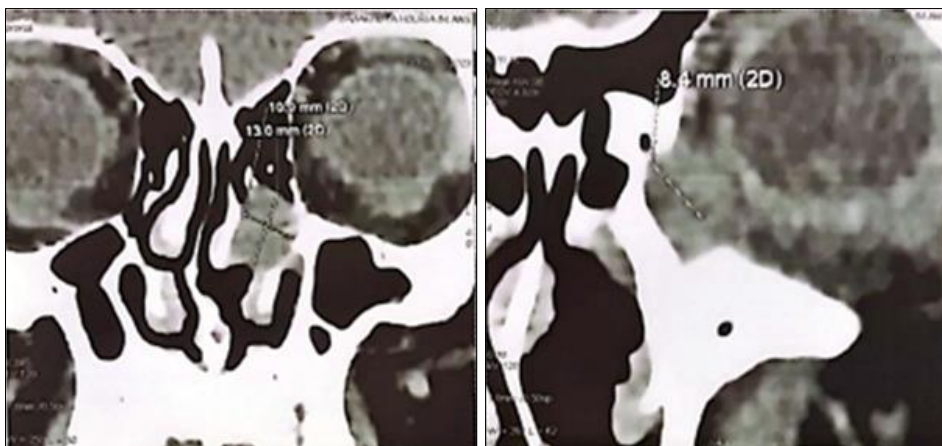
Computed tomography (CT) images showing a mass in the middle meatus with dilatation of the lacrimal sac
